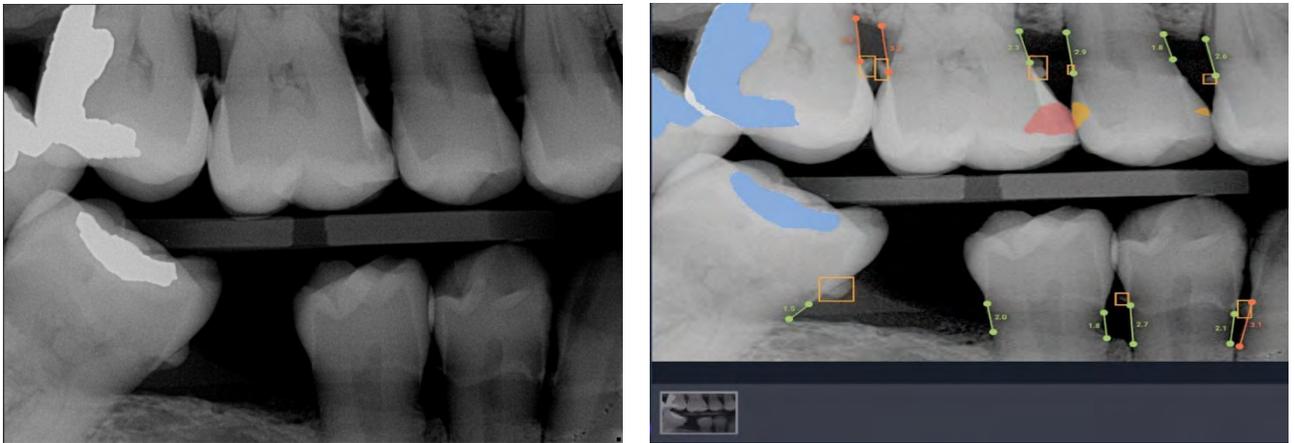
Example of how AI Technology can Illuminate a Black, White and Grey Radiograph with Quantified, Precision Outputs for Doctor Communication and Patient Education
